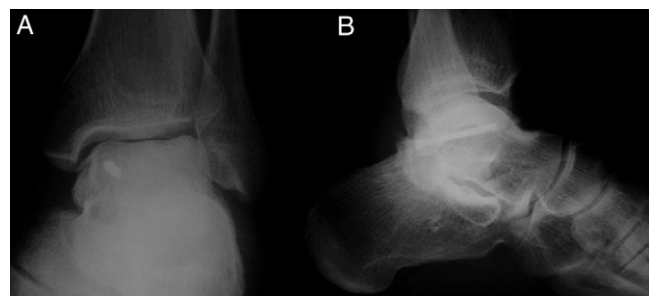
Postoperative 9-month follow-up anteroposterior (A) and lateral (B) radiographs of the repaired entire posterior process talus fracture without evidence of ankle or subtalar arthritis.
